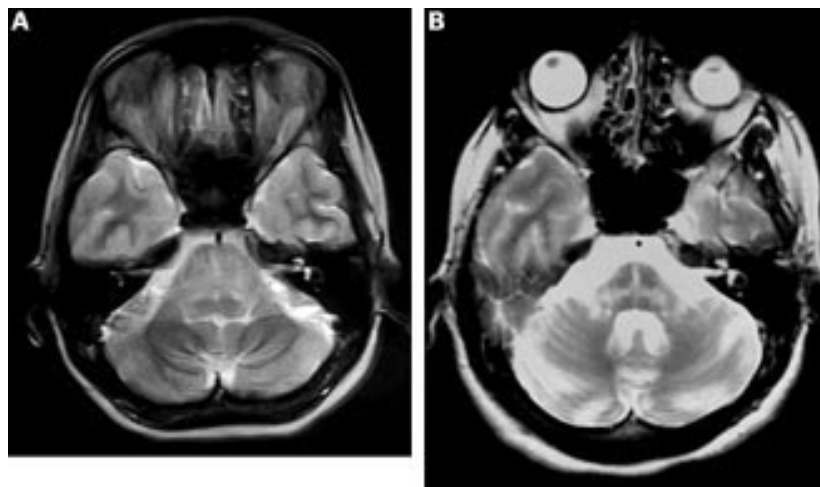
(A) Initial T2 weighted brain MRI of the patient disclosed non-enhancing pontine swelling. (B) Nine months later T2 weighted MRI showed severe atrophy of the medulla, pons, cerebellum, and middle cerebellar peduncles with cross shaped T2 signal hyperintensity within the pons (hot cross bun sign) and high signal change in the middle cerebellar peduncles.
